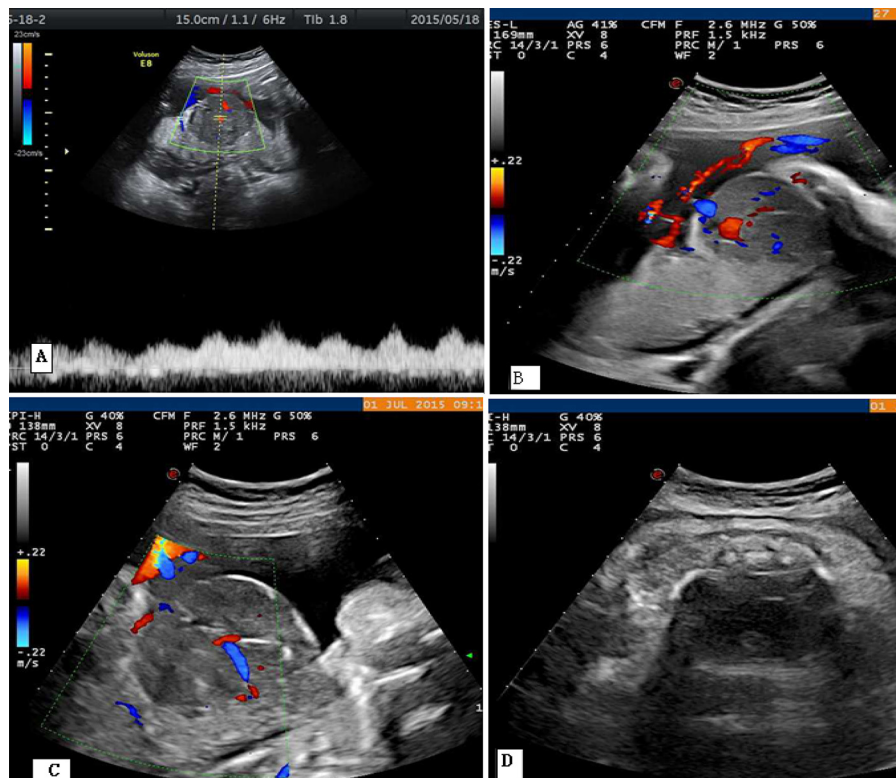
Sonographic features: (A) ultrasonography showing a placenta heterogeneous mass and spectral analysis shows low-resistance type of arterial flow within the mass; (B) the tumor were located close to the umbilical cord insertion site and contained numerous vessels; (C) tumor increased significantly as pregnancy continued. (D) cardiothoracic ratio increased as pregnancy continued; (from case 26).
